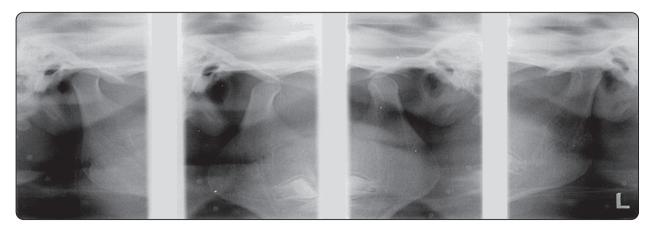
12 months postoperative radiograph showing condylar head behind articular eminence after ABI injection
